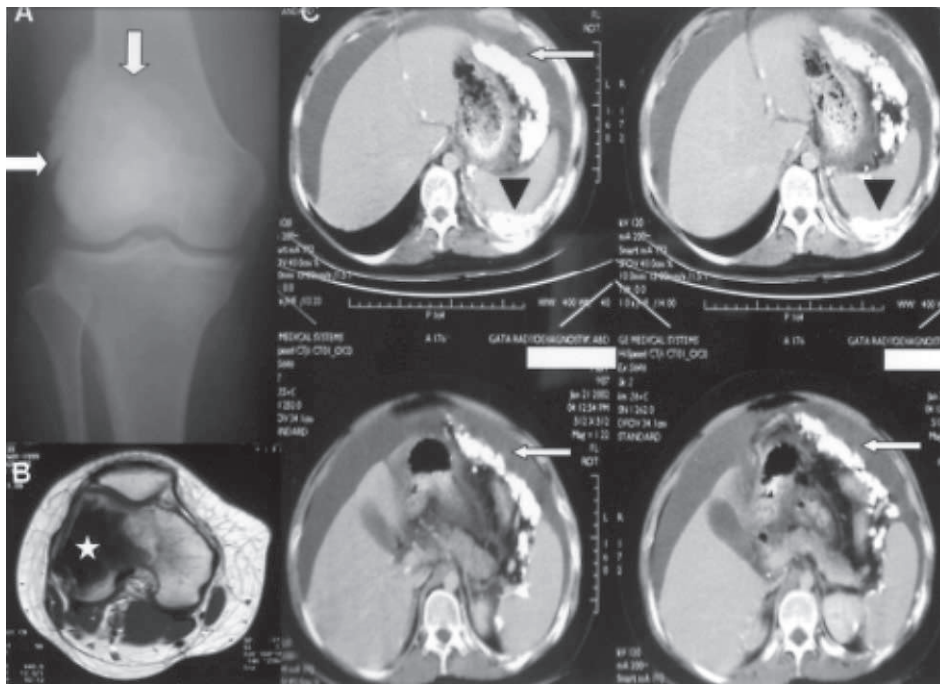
The x-ray of the primary tumor demonstrates the calcification within the mass (*arrows*) (A), and the MRI scan confirms that this osteosarcoma arises from the right distal femur (*star*) (B). Abdominal computerized tomography showing the presence of metastatic deposits in peritoneal cavity (*arrowheads*) and along the surface of the greater omentum (*arrows*) (C). Note the diffuse nature and punctuated pattern of the lesions.
